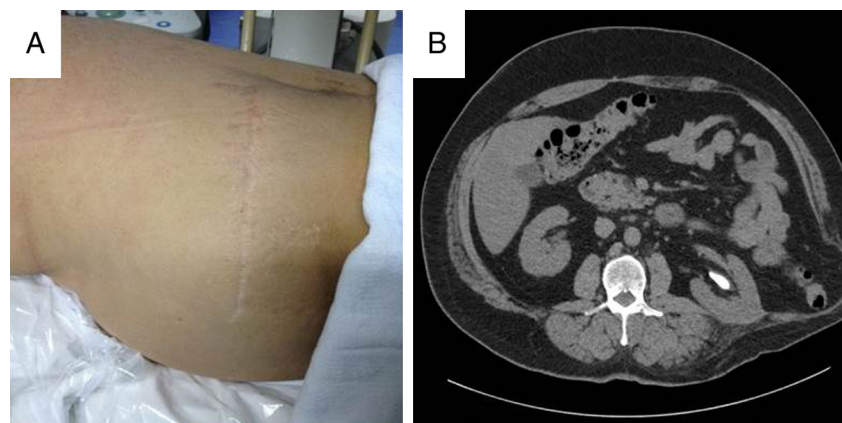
(A) Clinical picture of the flank incision and hernia bulge. (B) CT scan, showing the flank hernia, with bowel contents visualized within the sac, the 22 mm stone is visualized within the renal pelvis of the kidney.
